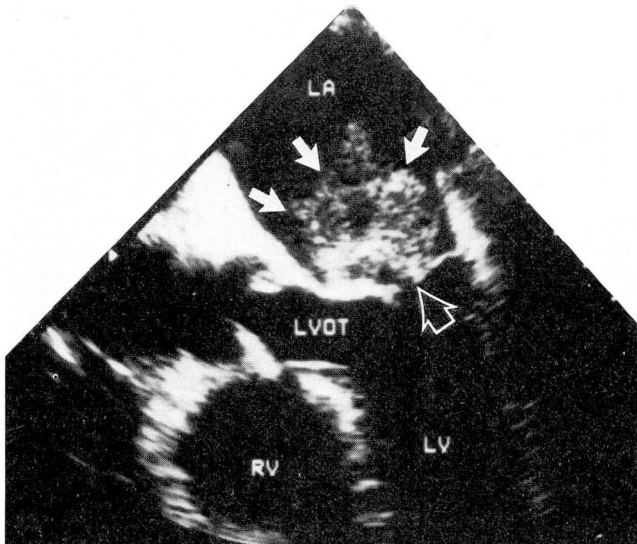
A two-dimensional echocardiogram obtained transesophageally, showing a large multilobulated lesion (solid arrows) of the left atrium abutting the mitral valve (open arrow). (RV, right ventricle; LV, left ventricle; LVOT, left ventricular outflow tract; LA, left atrium.)
